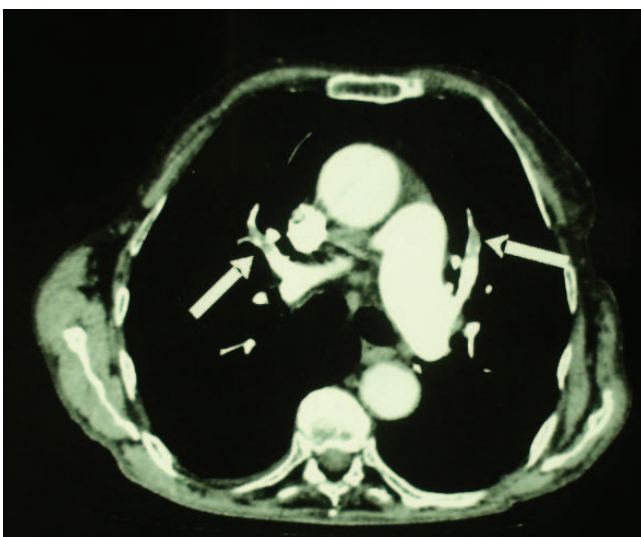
Multidetector computed tomography (MDCT) of the same patient (emboli are marked with a white arrow).
